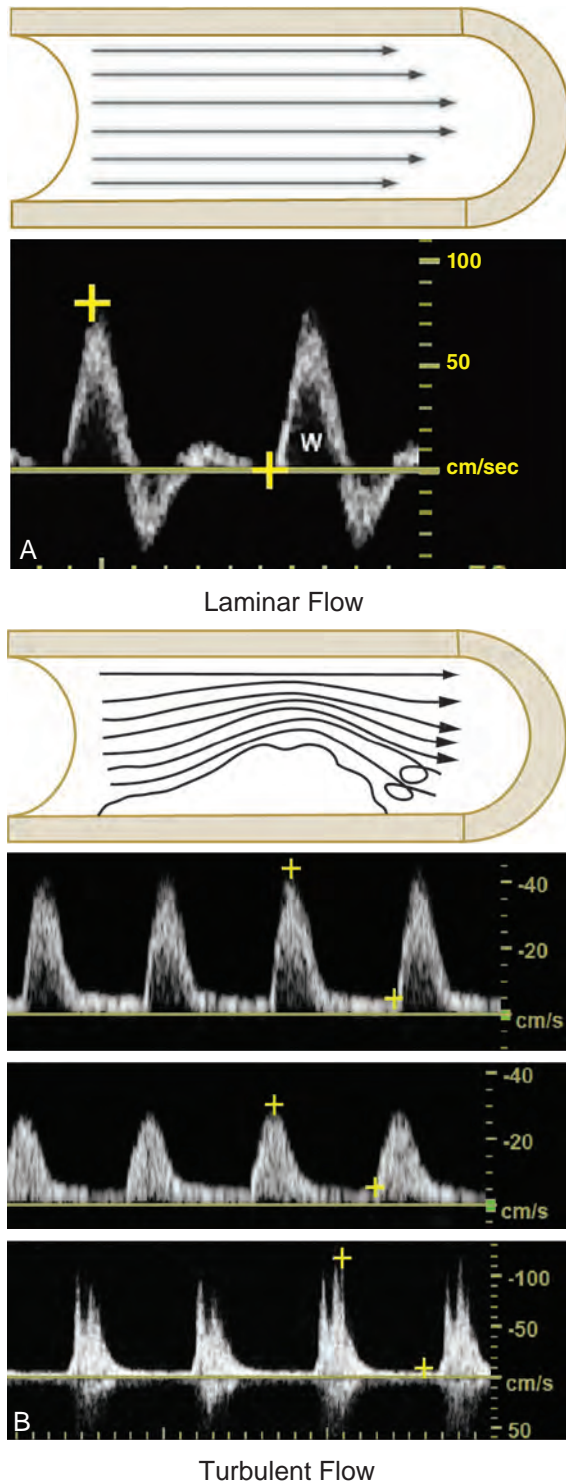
Blood flow through a vessel may be laminar or turbulent. (A) Laminar flow is the normal pattern of vessel flow, which occurs at different velocities, as flow in the center of the vessel is faster than it is at the edges. When the range of velocities increases significantly, the flow pattern becomes turbulent. The audio of the Doppler signal enables the sonographer to distinguish laminar flow from turbulent flow patterns. (B) Turbulent flow is the abnormal pattern of vessel flow that occurs when there is a narrowing in the vessel that causes a high velocity flow profile.
